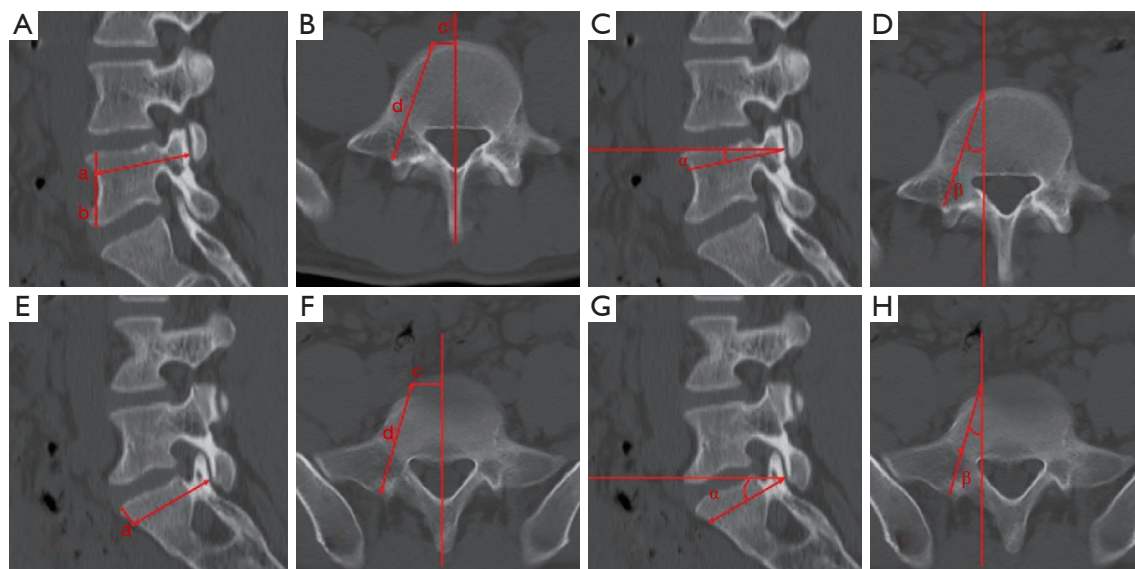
Radiographic parameter measurements of anterior projection in patients. (A,B,C,D) Show L5, and (E,F,G,H) show S1. Distance to upper endplate (a); distance to lower endplate (b); distance to midline (c); bone screw passageway length (d); sagittal screw angle (α); and transverse screw angle (β).
